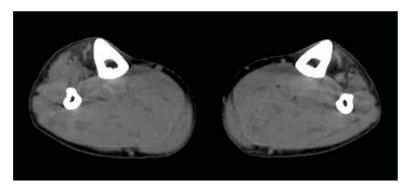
CT scans of lower leg muscles in a 50 year old male patient with FINmaj TMD mutation showing selective total fatty replacement of tibialis anterior muscles on both sides, severe change in extensors hallucis longus and digitorum longus on the left side and early changes only in these muscles on the right side. Normal appearance of the other lower leg muscles.
